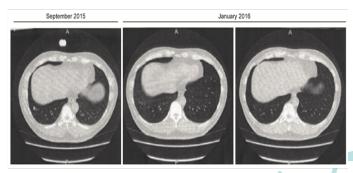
The left photograph shows a CT scan taken in September, 2015, center and right photograph show the CT scans taken in January and March, 2016.
